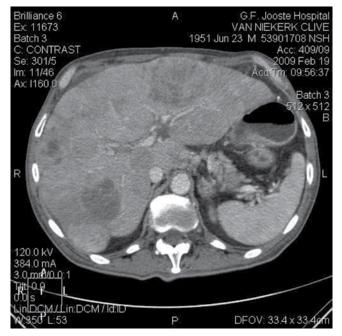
Contrast computed tomography of the abdomen at the level of T11 shows the markedly enlarged liver, with coexisting hypoechoic nodules, pathognomonic of metastatic disease
